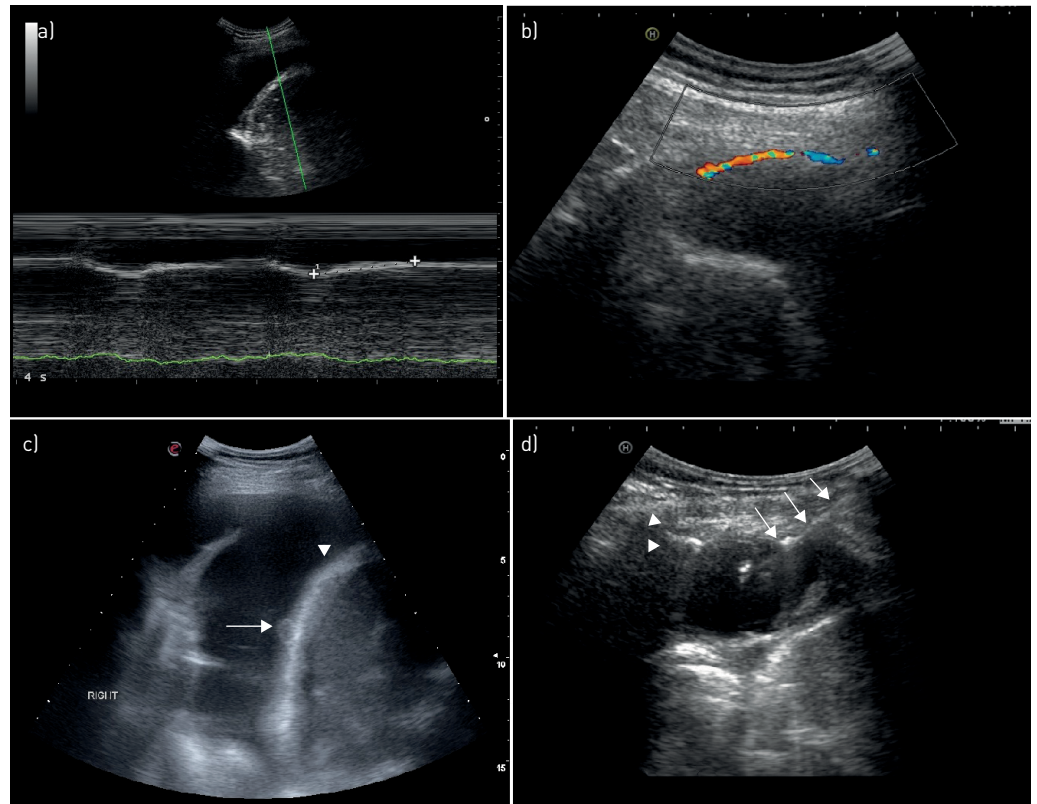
a) The upper part of the image is an ultrasound still in B-mode of pleural effusion and hemidiaphragm, with a green line traversing the middle. The lower part of the image corresponds to the M-mode image acquired for the structures traversed by the green line moving over time. Note the wavy white line and the + marks pointing to the degree of diaphragm excursion in one respiratory cycle. b) Doppler examination showing an unshielded intercostal vessel in the deep part of the chest wall. c) Right pleural effusion, collapsed lung and convex thickened hemidiaphragm [arrowhead]. Malignancy is confirmed by the presence of a nodule [arrow] on the diaphragm. d) Under real-time ultrasound guidance a core-cutting needle [arrows] is advanced to biopsy the parietal pleural thickening, the extent of which is indicated by two arrowheads.
